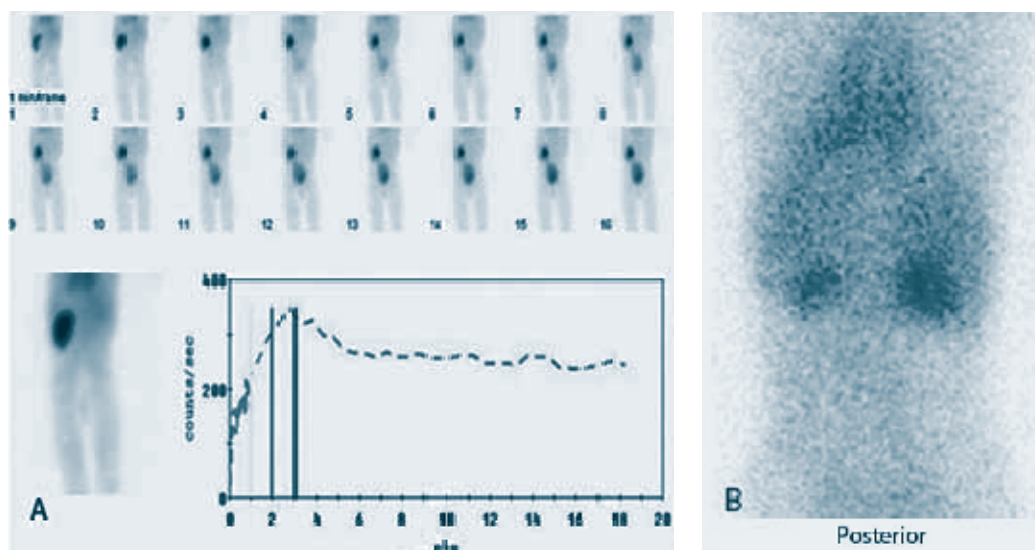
(A): Diuretic renal scintigraphy using ^{99m}Tc -DTPA. Left kidney shows good perfusion and cortical tracer uptake followed by unobstructed drainage. (B): ^{99m}Tc -DMSA renal cortical scintigraphy reveals grossly increased background tracer activity. Severely impaired tracer uptake by both kidneys is noted suggesting bilateral severely impaired renal function.
